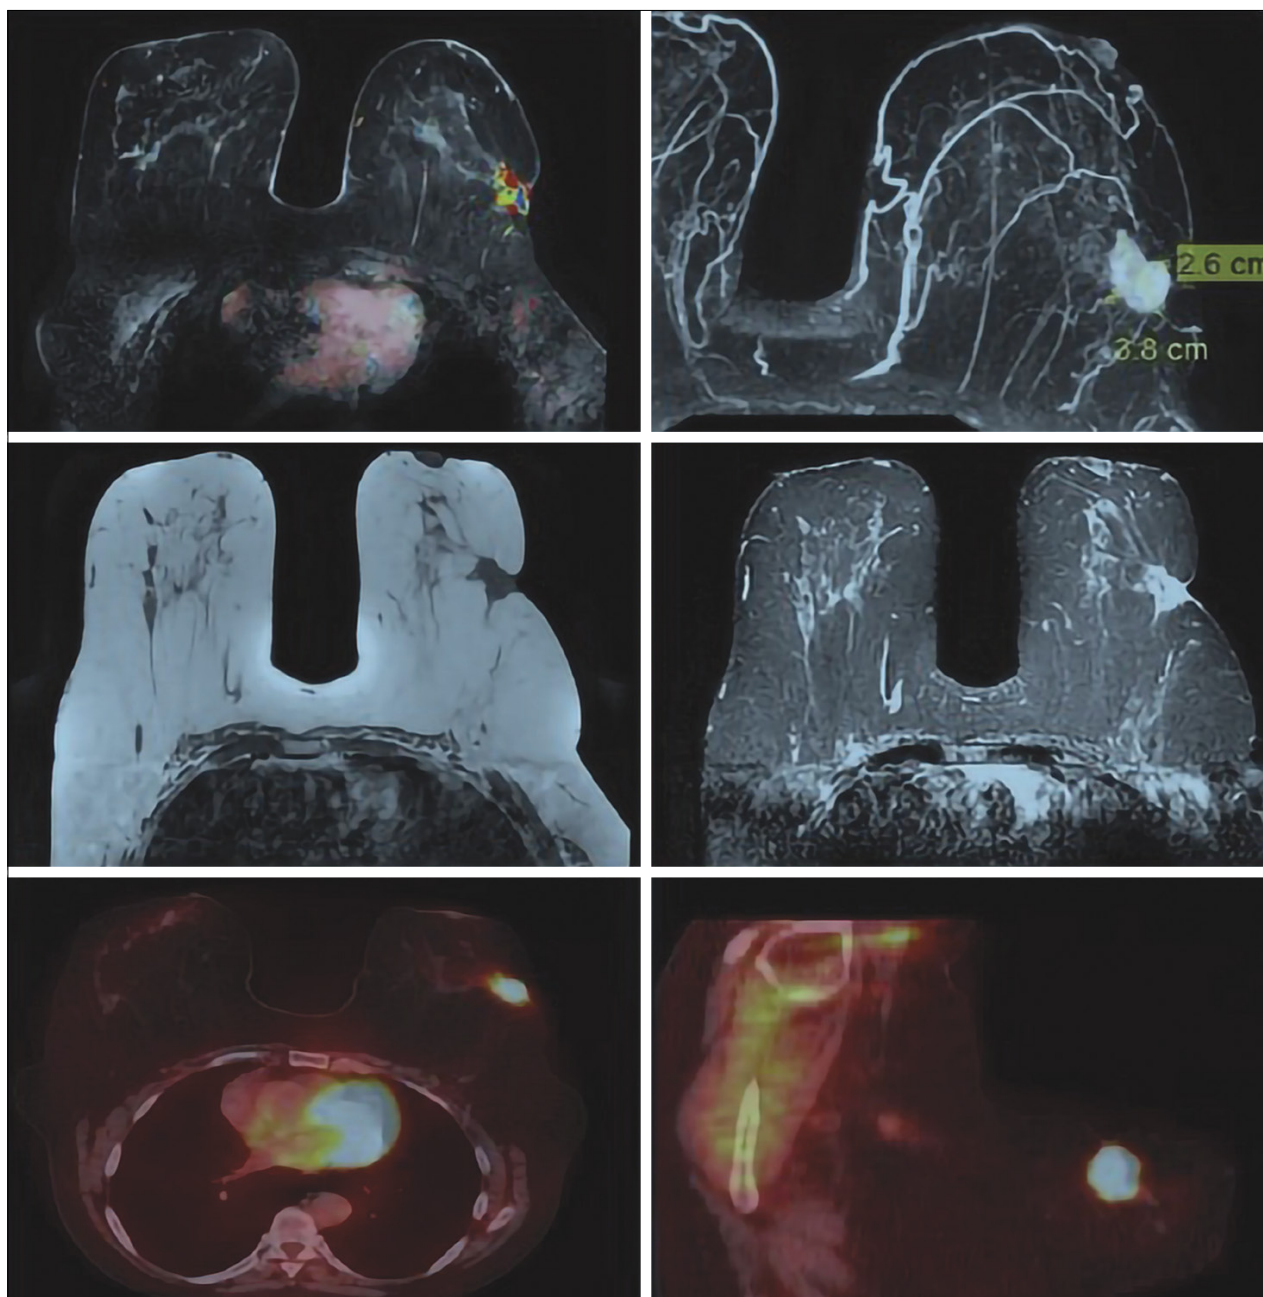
Sixty-six years old, left breast invasive ductal carcinoma, Grade 2, non-luminal tumor, tumor dimensions on MRI 38×16×29 mm, spherical volume: 9.1 cc, angiovolume: 9.4 cc, peak signal intensity: 187 (upper and middle row), SUV_{max} : 14.4 (bottom row).
